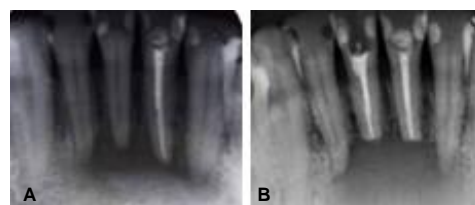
A – Radiographic image evidencing radiolucent periapical lesion in lower central incisors.; B - Radiographic image post apicectomy.
